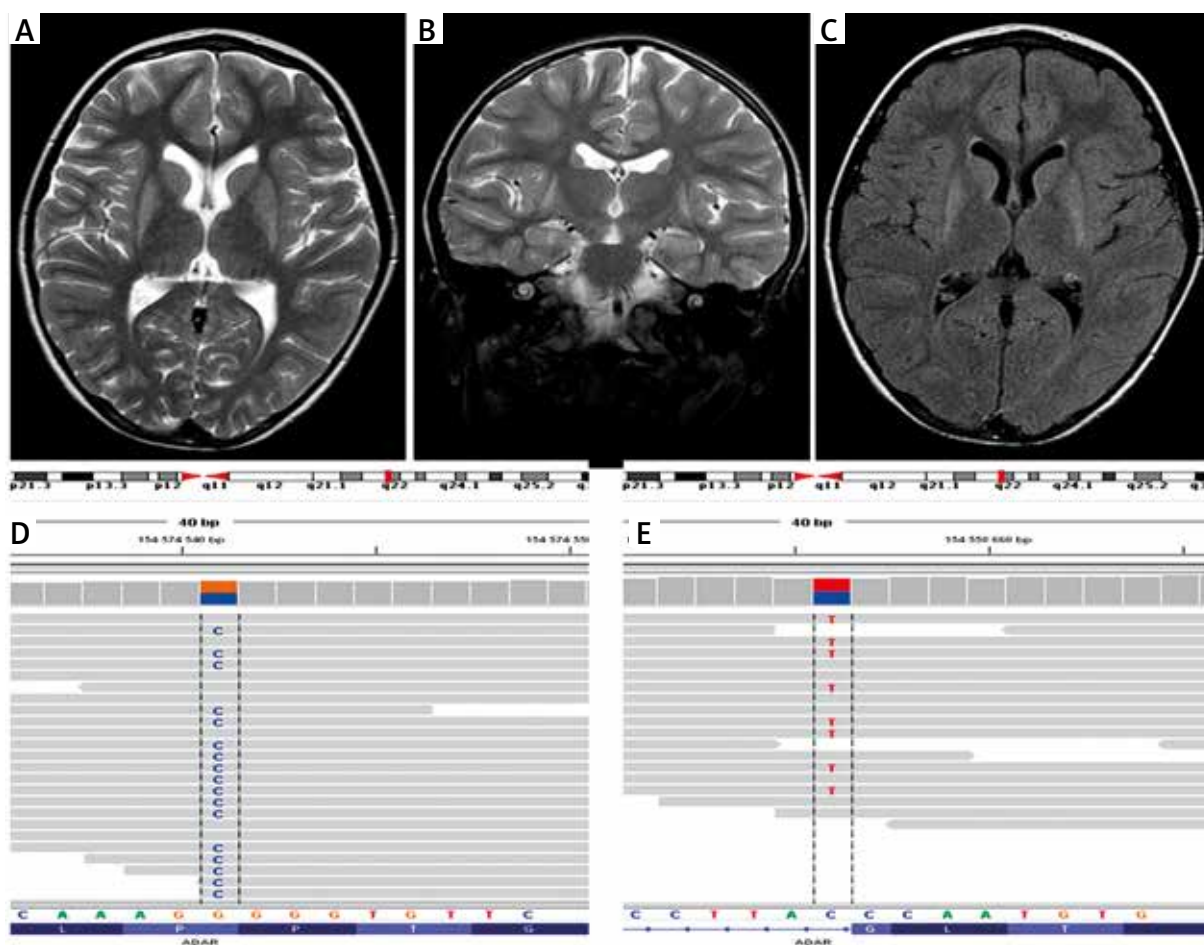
Magnetic resonance imaging and molecular findings revealed in Case 1. A-C) Bilateral involvement of the putamen with hyperintense signal on T2-weighted images: axial plane, coronal plane, and on FLAIR sequence, respectively. D, E) Integrative Genomics Viewer picture of identified *ADAR* causative variants c.577C>G and c.3202+1G>A. The depth of coverage across the variants was 8/16 and 18/37, respectively
